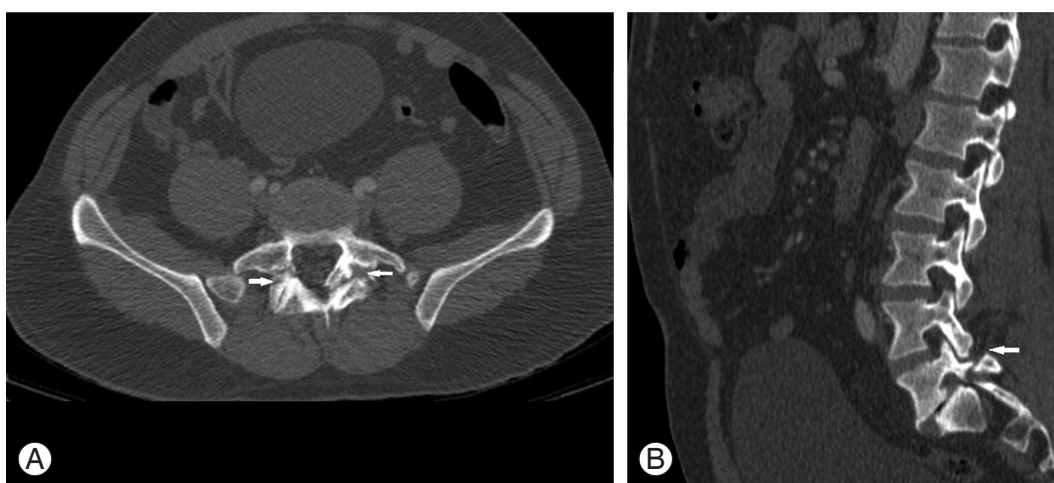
Computed tomography scan bone window of a 38-year-old male presenting with severe pain in the epigastric region. (A) Axial images showing a bilateral pars interarticularis fracture (arrows). (B) Sagittal reconstruction of the same patient showing a fracture of the pars interarticularis involving L5 with grade II spondylolisthesis (arrow). Mild degenerative changes were also seen with vacuum phenomena at the L5/S1 level.
